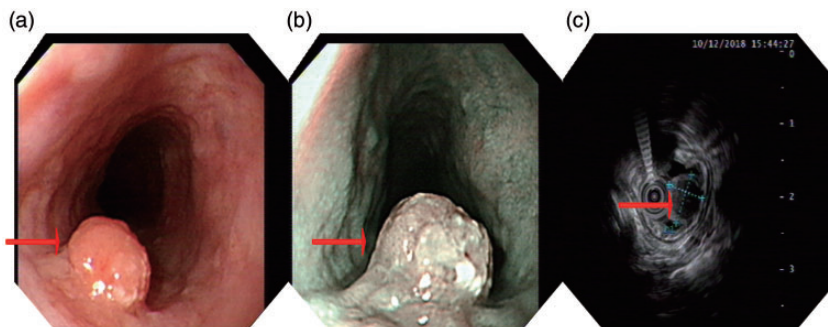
Endoscopic appearance. (a) A protruding lesion with a smooth surface was observed within a shallow depressed area in the proximal third of the esophagus. (b) Chromoendoscopy with narrow band imaging demonstrated a polypoid lesion and normal mucosa covering part of the surface. (c) Endoscopic ultrasonography demonstrated a hypoechoic tumor, 11 mm in diameter, confined to the submucosa with a smooth, well-demarcated and smooth outline and intact muscularis propria layer.
